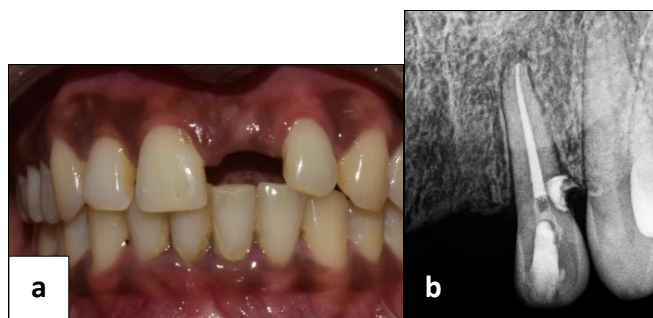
a) Postoperative photograph after 2 weeks; b) Post obturation radiograph
